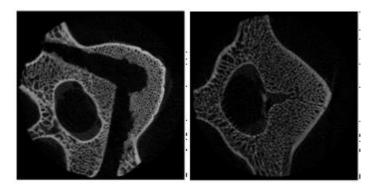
11: Micro CT imaging. Vertebra with defect, Vertebra filled with bone cement
